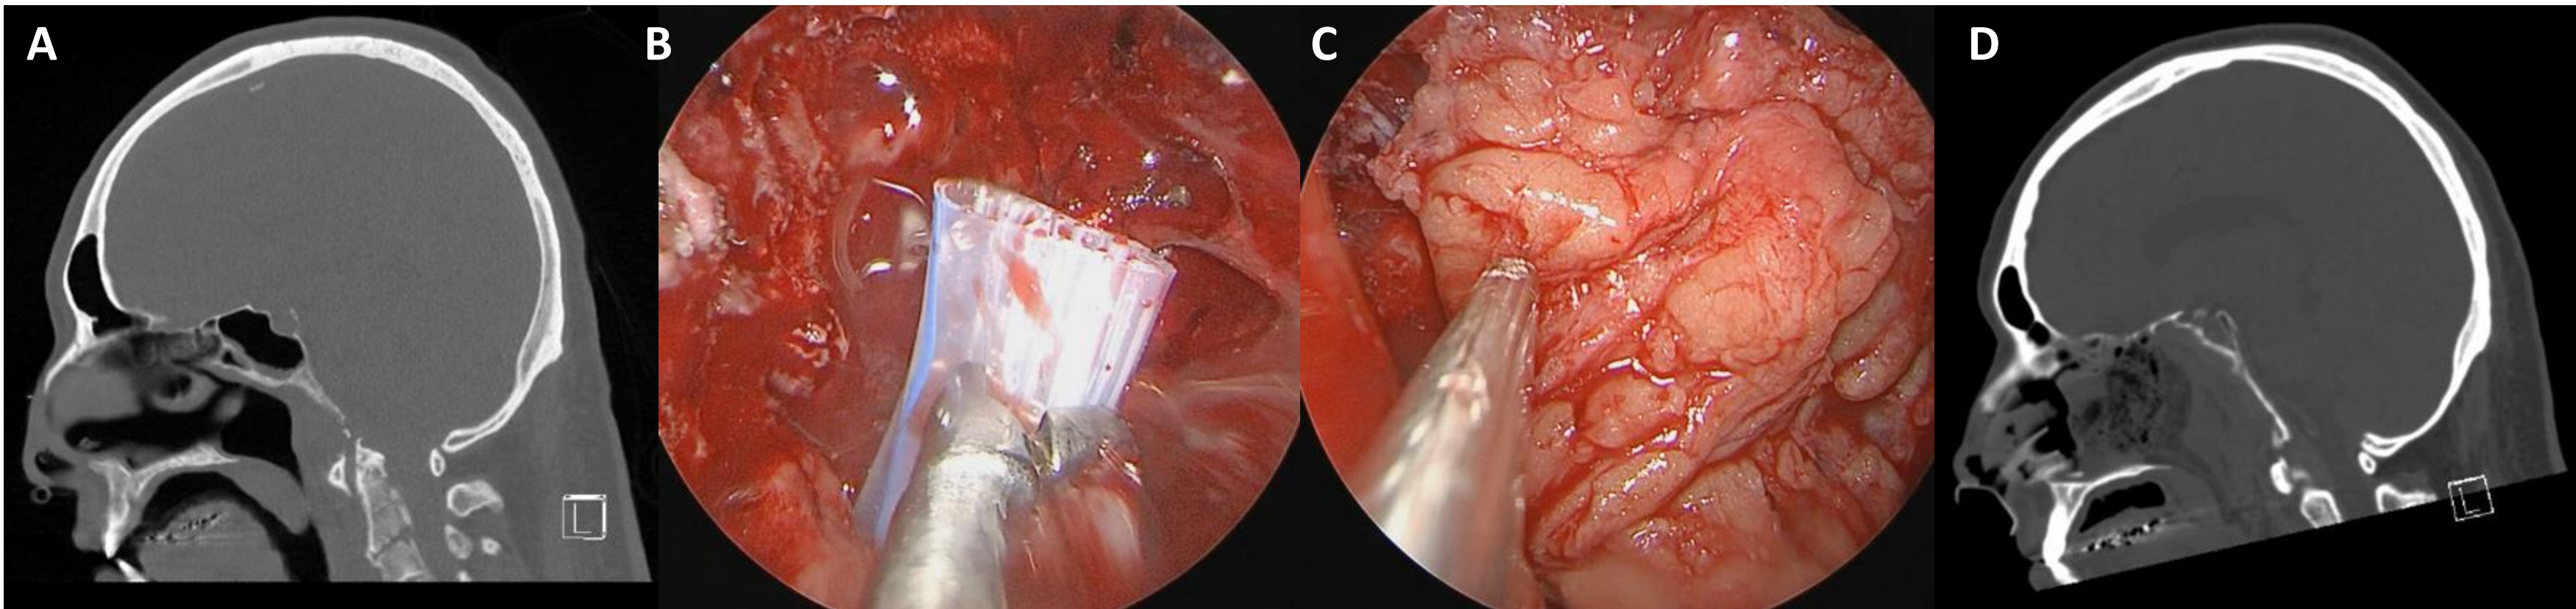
A) Sagittal view of pre-operative CT scan showing clival defect. B) Pulling penrose through retropharynx to create tunnel for flap inset. C) Endoscopic inset of flap after placement through retropharyngeal corridor. D) Sagittal view of post-operative CT scan showing flap in place along clivus.
